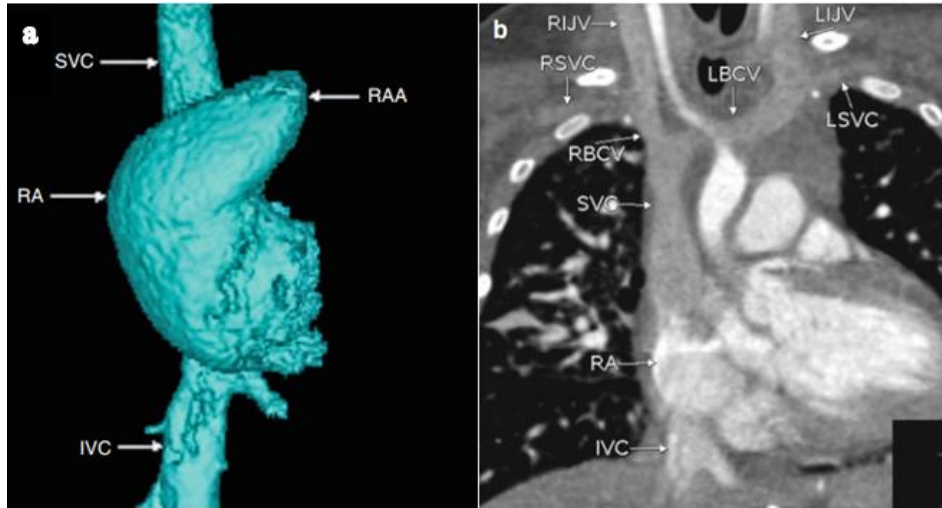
3D CT color coded anterior view (a) and CT coronal MIP view (b) image showing RA with RAA and systemic venous drainage (*Quoted from Richardson, 2013*).
